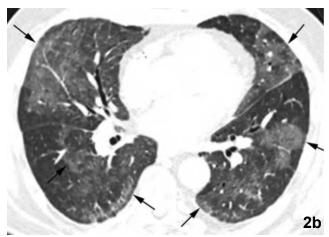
Coronal reformat (a) and axial (b) CT, performed three weeks after the CT shown in Figure 1, shows interval worsening of ground glass opacities (arrows). Thalidomide therapy was discontinued at this time.
